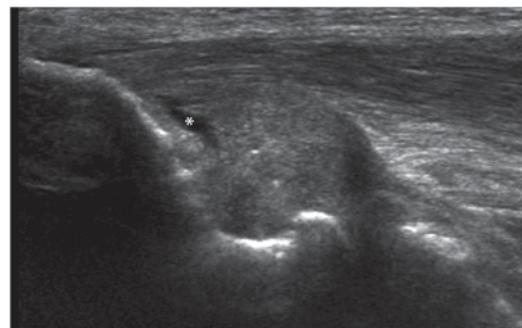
Longitudinal ultrasound view of the thickened anterior band of the UCL with a focal tear (*)
